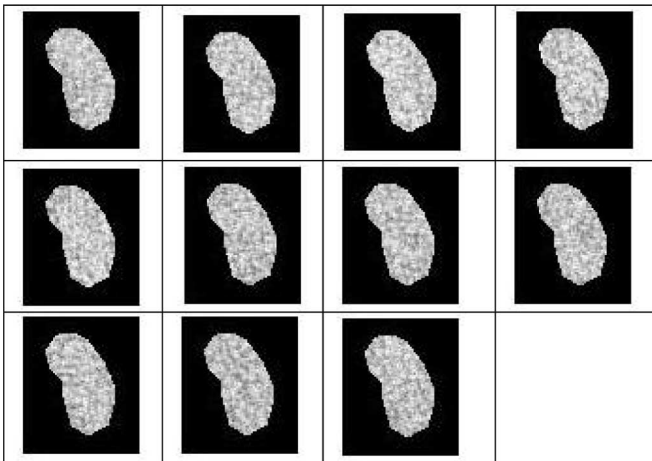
From left to right—11 ROIs extracted from 11 successive CT images with slice 3 giving the highest FD_{avg} .
